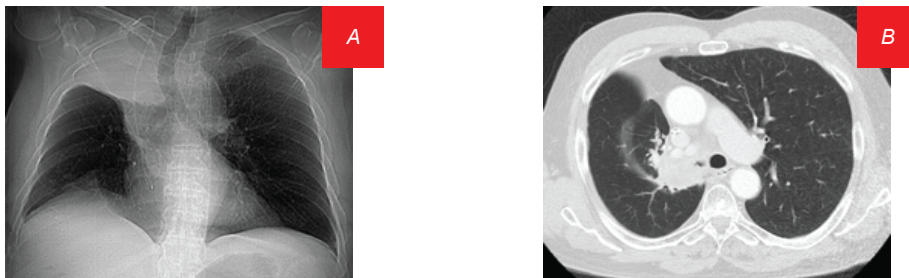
A) Chest CT scout film and axial cut demonstrating atelectasis B) Severe narrowing of right main bronchus.
